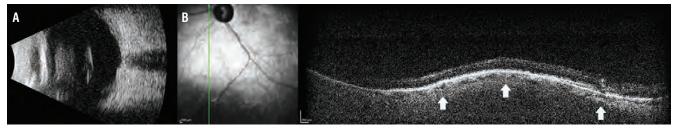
B-scan ultrasonography shows a 2.3 mm elevation of the solid lesion inferior to the optic disc (A). EDI-OCT over the lesion shows scleral elevation (arrows) rather than choroidal thickening. Normal retinal architecture was maintained over the lesion, and no SRF or edema was noted (B).
